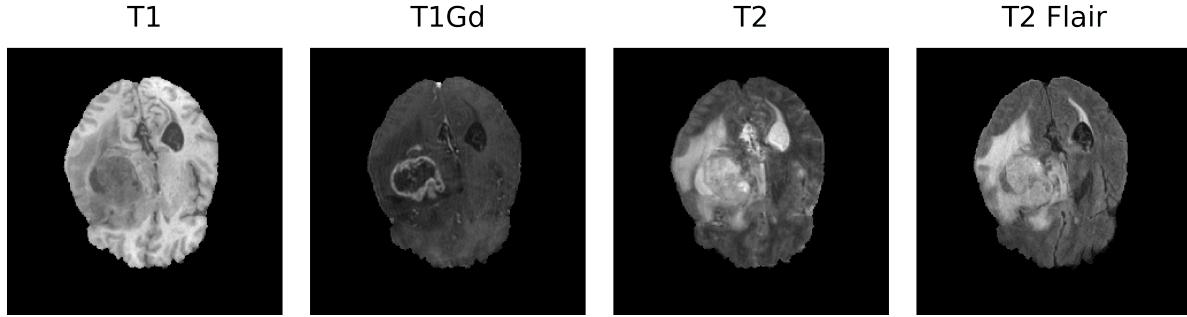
Different MRI modalities in the BraTS dataset. There are 155 axial slices in each volume, and each slice is 256×256 . Each subject has four MRI modalities: T1, T1Gd, T2, and T2 Flair.
